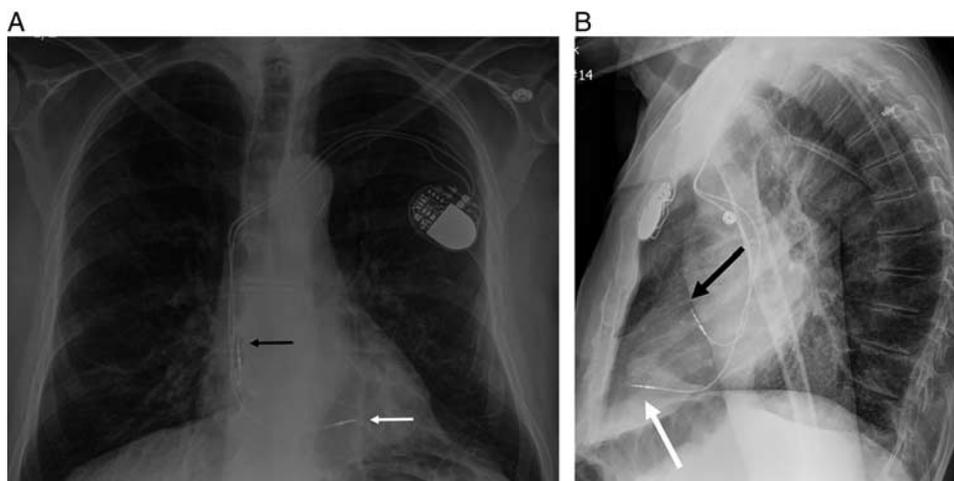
Permanent dual-lead transvenous pacemaker: frontal (A) and lateral (B) radiograph depicting dual-lead pacemaker with lead tips in the right atrial appendage (black arrow) and right ventricular apex (white arrow).
